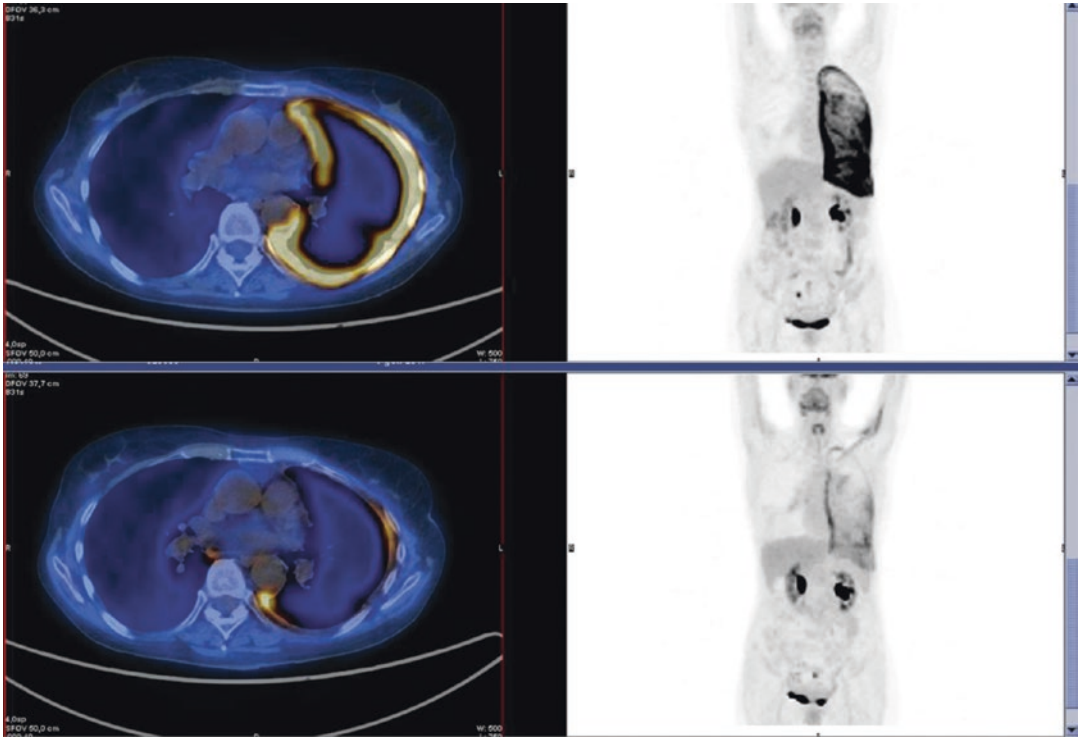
^{18}F FDG PET/CT is valid in assessment of tumour response in patients undergoing chemotherapy. Upper panel shows imaging before chemotherapy. Lower panel shows significant reduction of activity after two cycles of therapy
